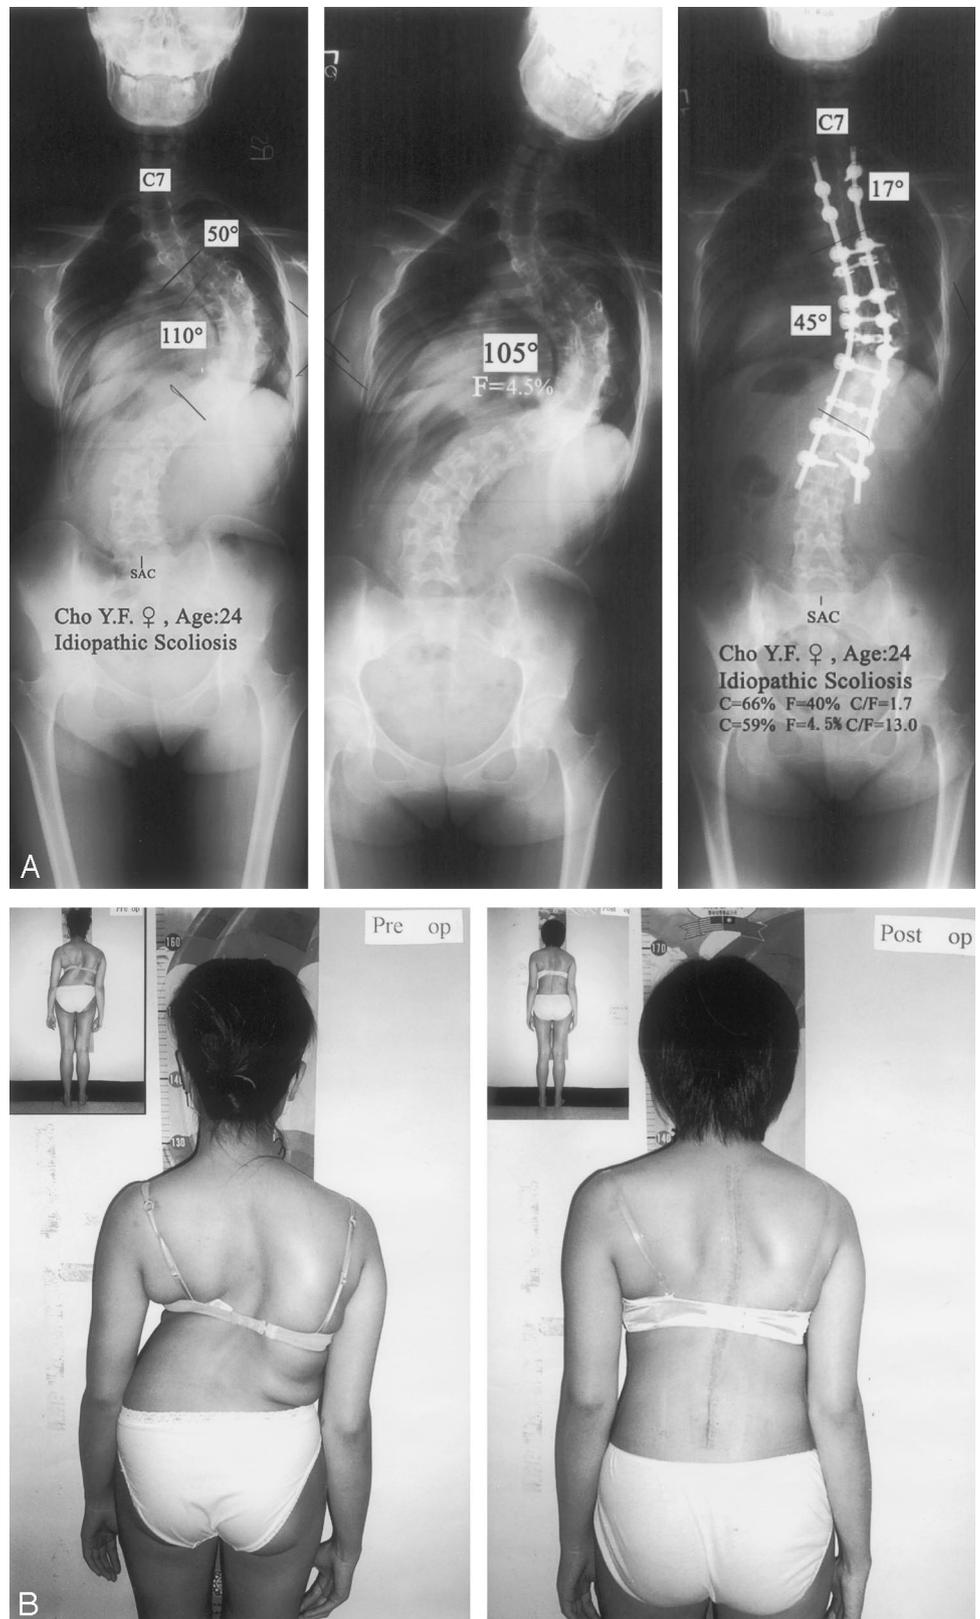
A 24-year-old female with a 110° King V idiopathic scoliosis. Radiographic views show (A) preoperative AP side-bending and postoperative AP. B, Preoperative and ultimate postoperative clinical appearance.
